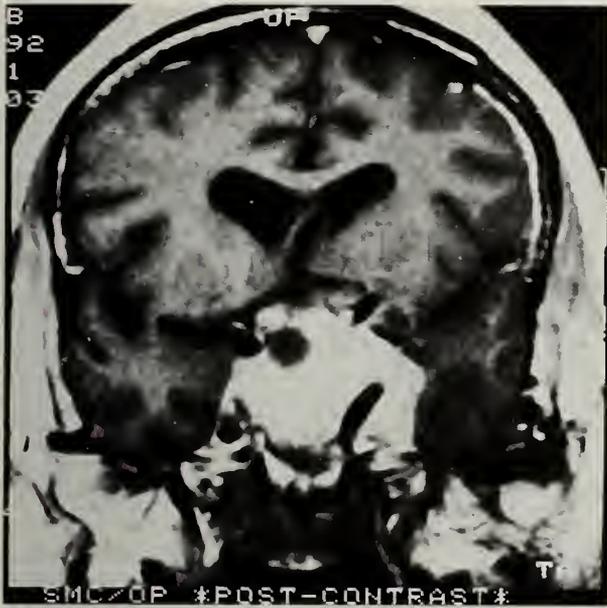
Temporolimbic tumor.* Patient 7 had 2 months of panic attacks, and this T1-weighted, enhanced coronal magnetic resonance image shows a pituitary macroadenoma extending into the left temporal lobe and thalamus and compressing the right medial temporal lobe (TR = 45 msec, TE = 15 msec). Debulking eliminated the panic attacks.
